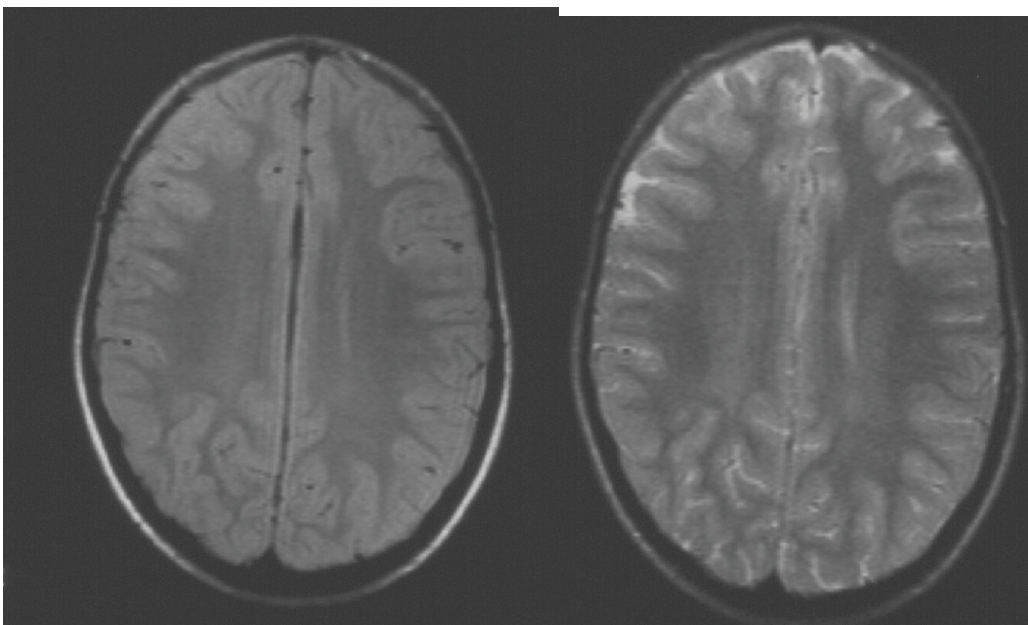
cMRI of proband T.H. Note the hyperintensity located on the medial, occipital aspect of the left posterior horn. T1-weighted image on left, T2-weighted image on right side.
